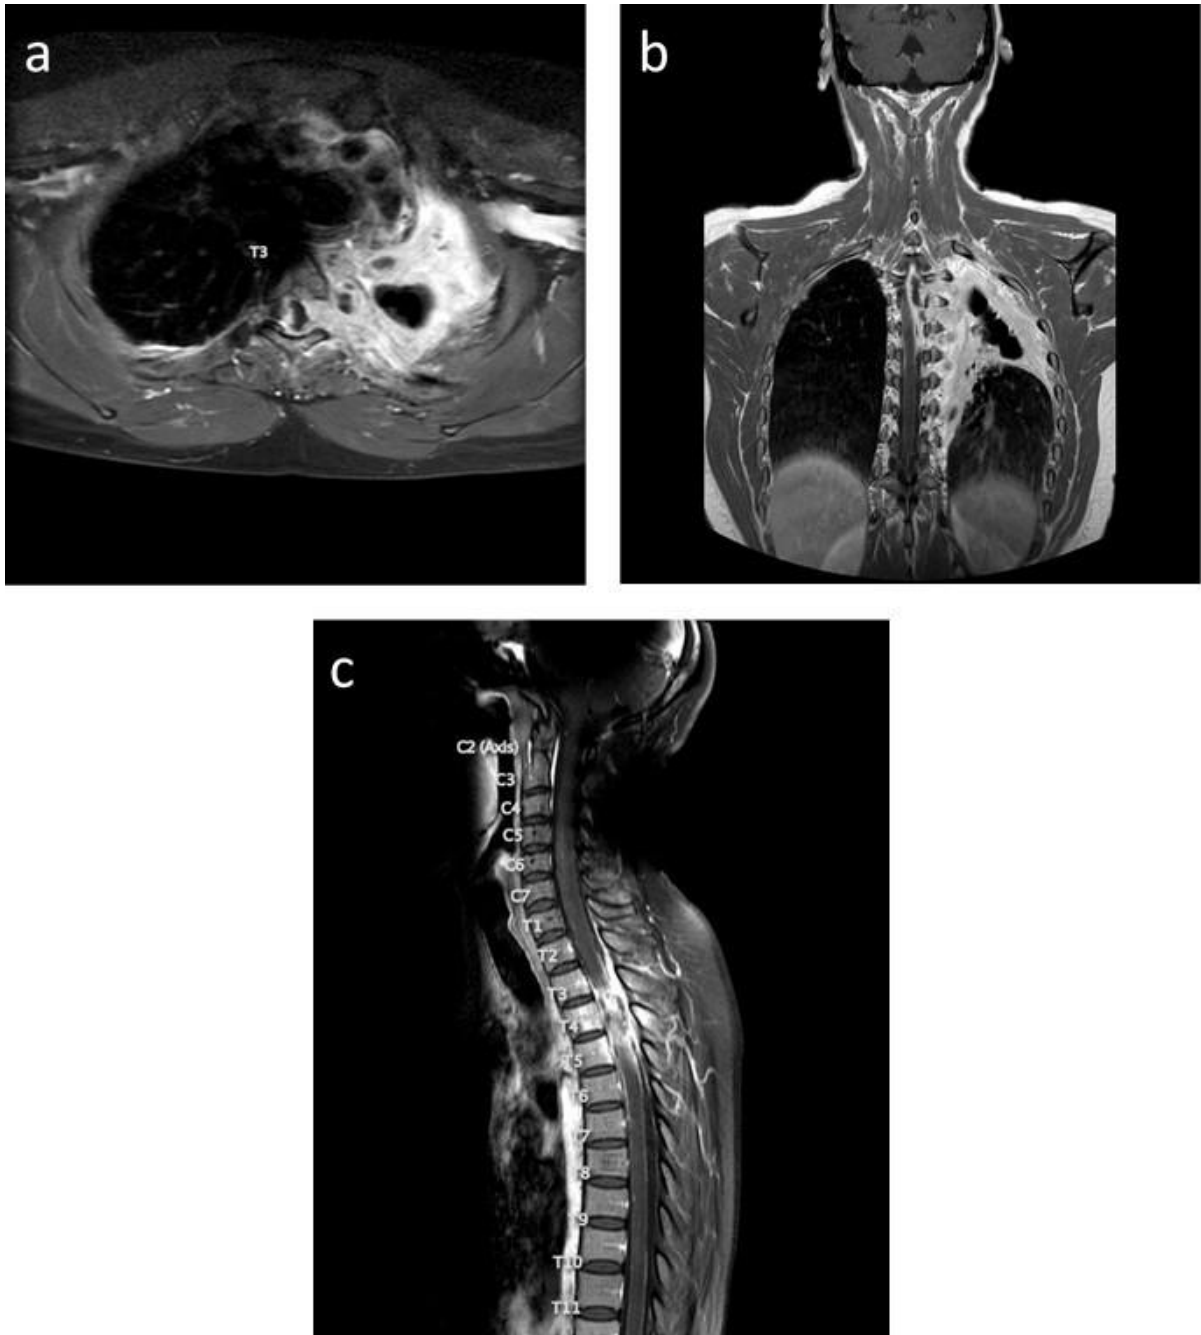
MRI images of a) transverse plane, b) coronal plane and c) sagittal plane showing left upper lobe cavitation, thickened and enhancing medial pleura and left para-spinal soft-tissue, with multiple small pockets of non-enhancing fluid collections. This can be seen extending into the spinal canal via the left T3/T4 and T4/T5 neural foraminae encasing the exiting nerves. An irregularly rim enhancing intraspinal, extradural collection can be seen
